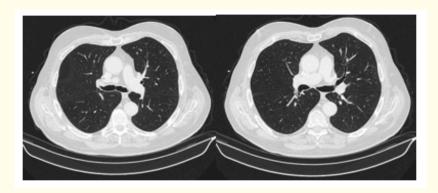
Computed tomography 12 month follow up.
